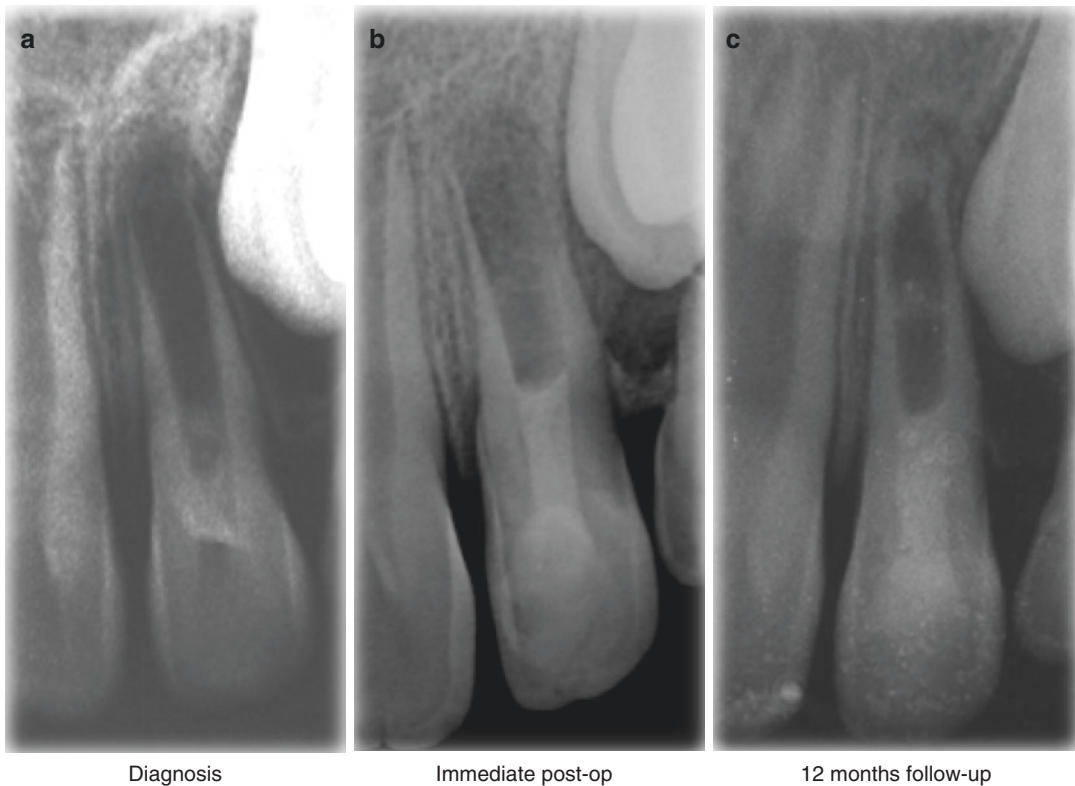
A 15 yrs old female patient presented with an open apex right upper central incisor, diagnosed with pulp necrosis, acute apical abscess, and a large periapical lesion (The adjacent lateral incisor was also diagnosed with pulp necrosis, and was scheduled for a routine endodontic treatment) (a). Following non-surgical root canal treatment, a calcium hydroxide paste was used as an inter-appointment intra-canal medicament.
